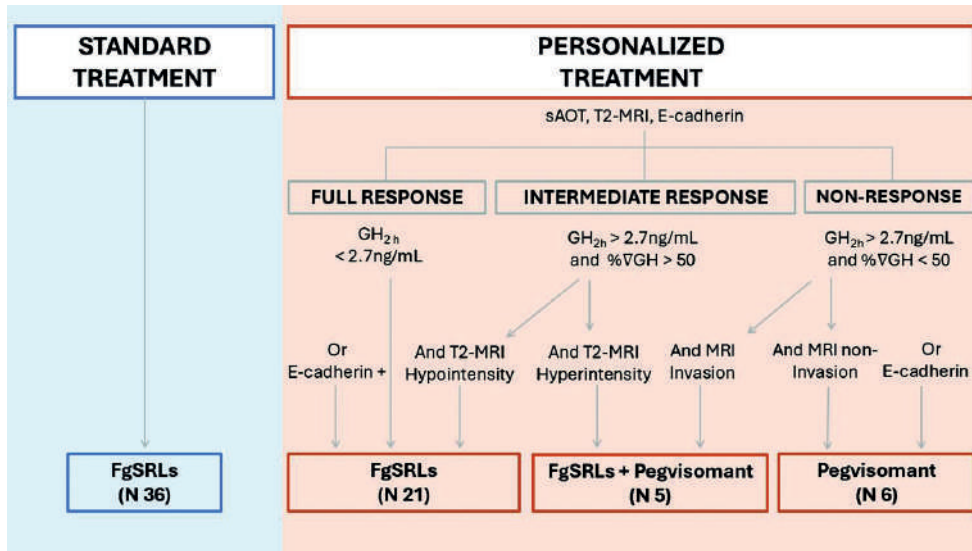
Treatment algorithms. After inclusion, patients were treated according to the standard treatment or a personalized treatment based on the short acute octreotide test (sAOT), T2-MRI intensity, and the expression of E-cadherin. Abbreviations: fgSRLs, first-generation somatostatin receptor ligands; GH, growth hormone; GH_{2h}, growth hormone value 2 hours after the short acute octreotide test; MRI, magnetic resonance imaging; PEGV, pegvisomant; %VGH, percentage GH variation after the short acute octreotide test; (PEGV).
